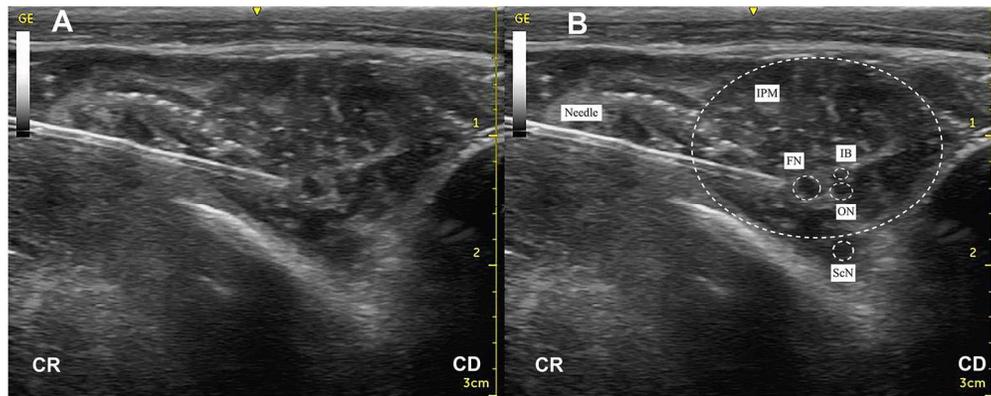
Ultrasound image of the femoral nerve (FN) and the obturator nerve (ON) at the target level. The left side is the cranial (CR) side and the right side is the caudal one (CD). The nerves are visible as hypoechoic holes: the FN is the most cranial near to the needle, the ON is recognizable as a hypoechoic structure caudal and lower to the FN. Caudally to the FN it is possible to recognize another structure that represents the iliac branches (IB) of the FN. The sciatic nerve (ScN) is merely visible outside the belly of the iliopsoas muscle (IPM).
